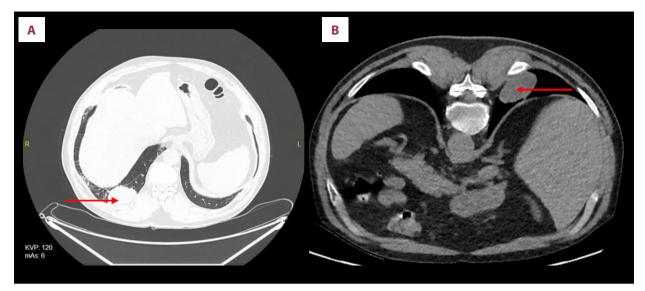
CT scans of the chest (A: pulmonary window, B: mediastinal window) of a patient with a hematoma. Red arrows denote a focal lesion with a diameter of 48 mm, which turned out to be a hematoma.
